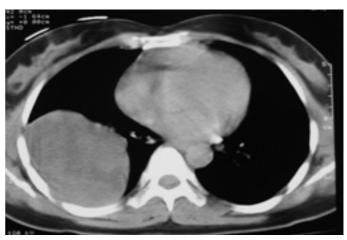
Computed tomography of the thorax shows a 8×6 cm cystic mass lesion on lower, lateral and posterior lung field.
